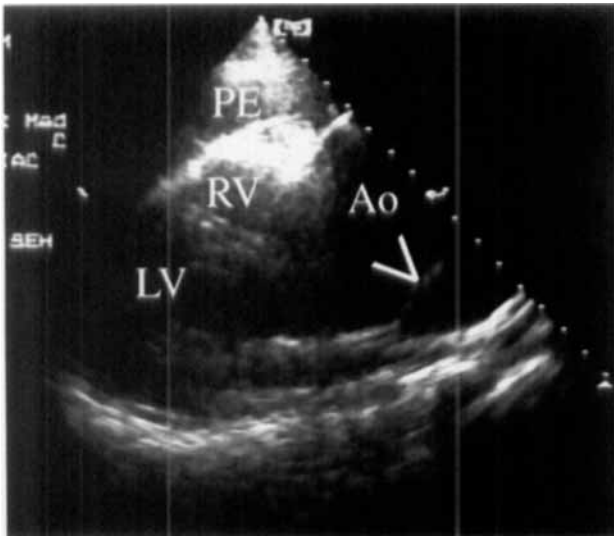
Transthoracic echocardiogram in Case No. 1: Parasternal long-axis view showing markedly dilated aortic root (Ao) at right with dissection flap (arrowhead). Pericardial effusion (PE) is seen at top, adjacent to right ventricular (RV) free wall. LV = left ventricle.
